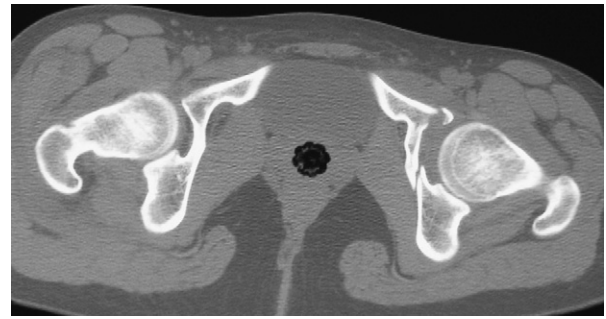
CT scan pelvis after closed reduction.
